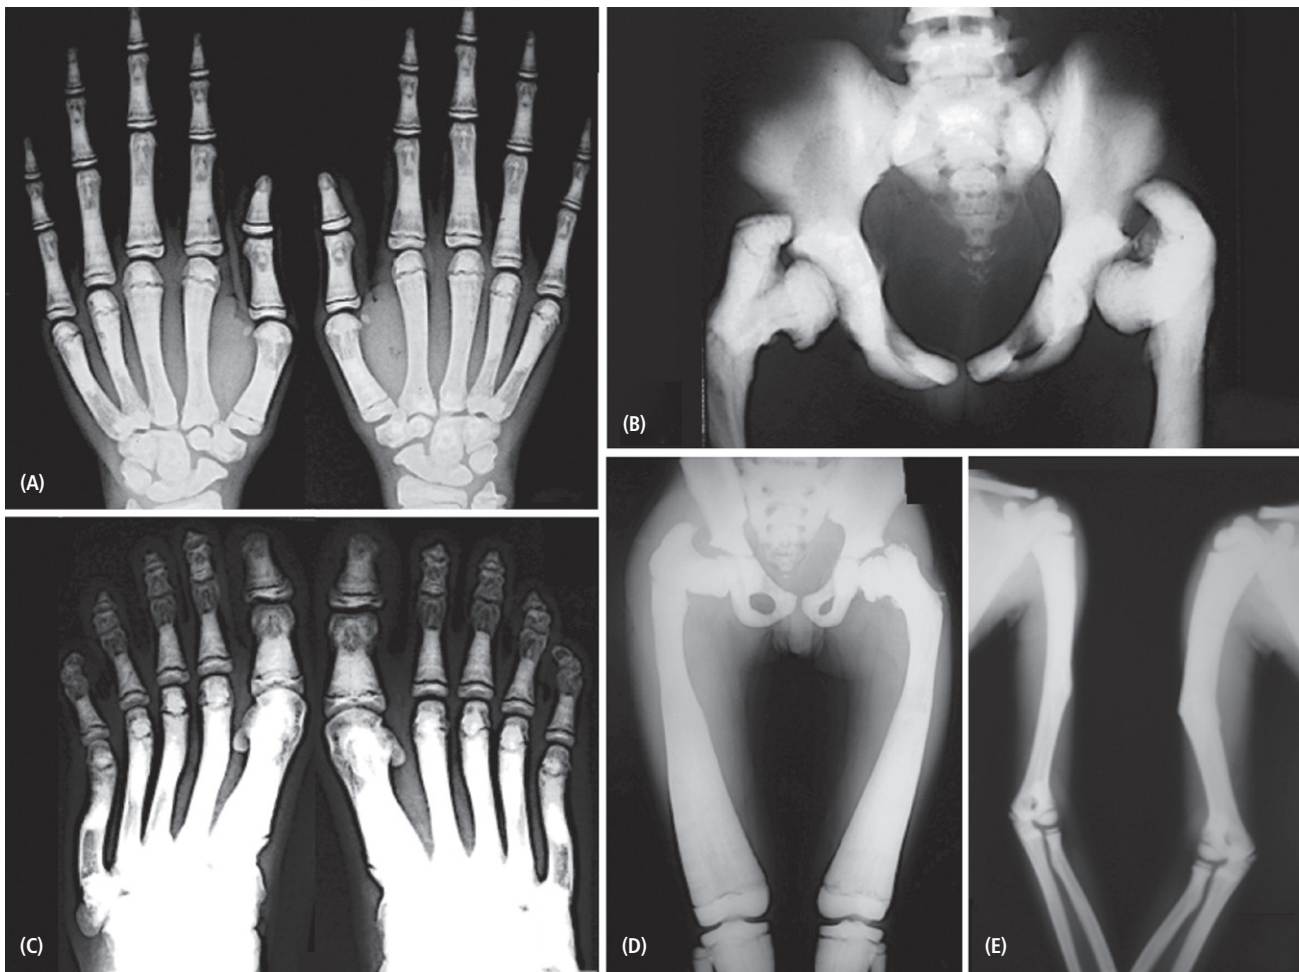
A–E. Generalized osteoclerosis. Pelvic radiographs (B and D) demonstrate severely malformed pelvis and femoral heads. Acetabula are abnormally shallow. Superior pubic ramus, inferior pubic ramus, and ischial tuberosity are severely hypoplastic. The iliac crests are less sclerotic. The heads of the femora are sclerotic with irregular foci of sclerosis. Greater trochanters are abnormally prominent. There is metaphyseal clubbing of the femora. Fracture deformities of the humeri are evident on the humeri (E).
